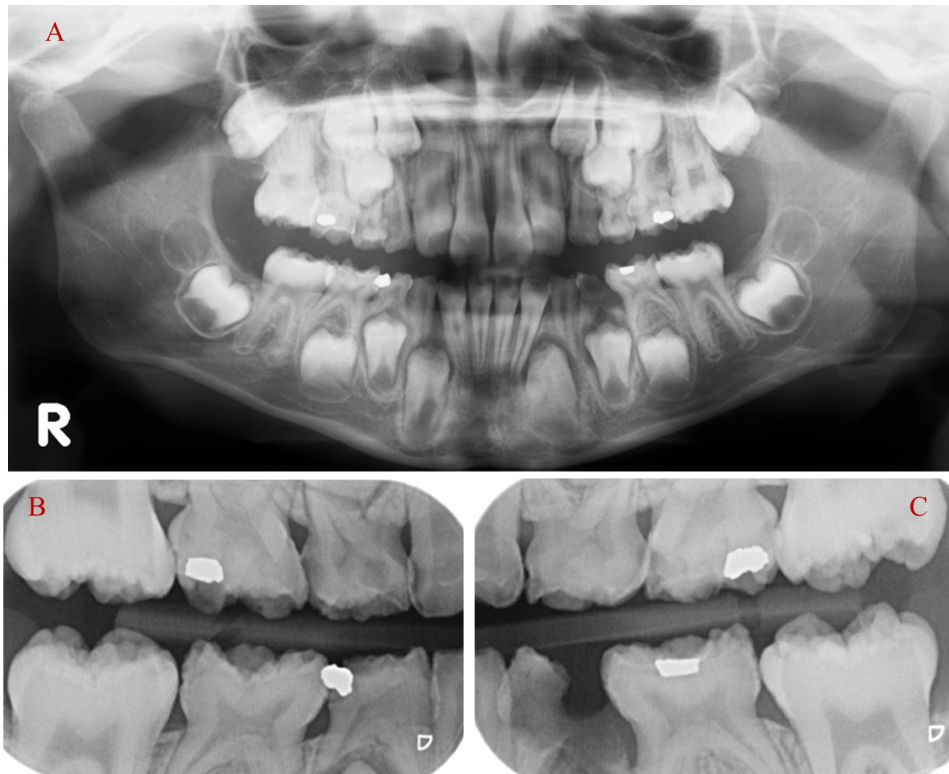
Pre-treatment intra-oral radiographs. (A) orthopantomogram radiograph, (B) right bitewing radiograph, and (C) left bitewing radiograph.
